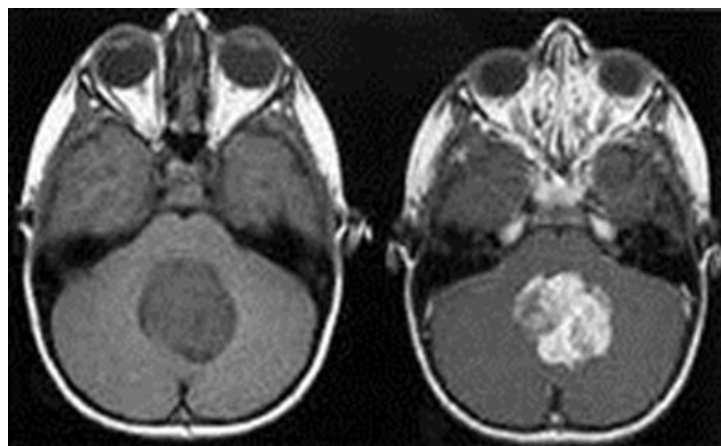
MRI image of medulloblastoma
